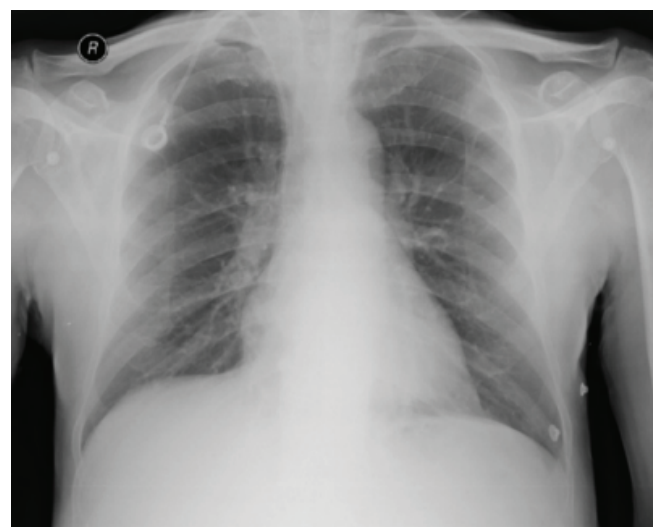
The postoperative control posteroanterior (PA) chest radiograph was evaluated, and no acute pulmonary complications were observed.
